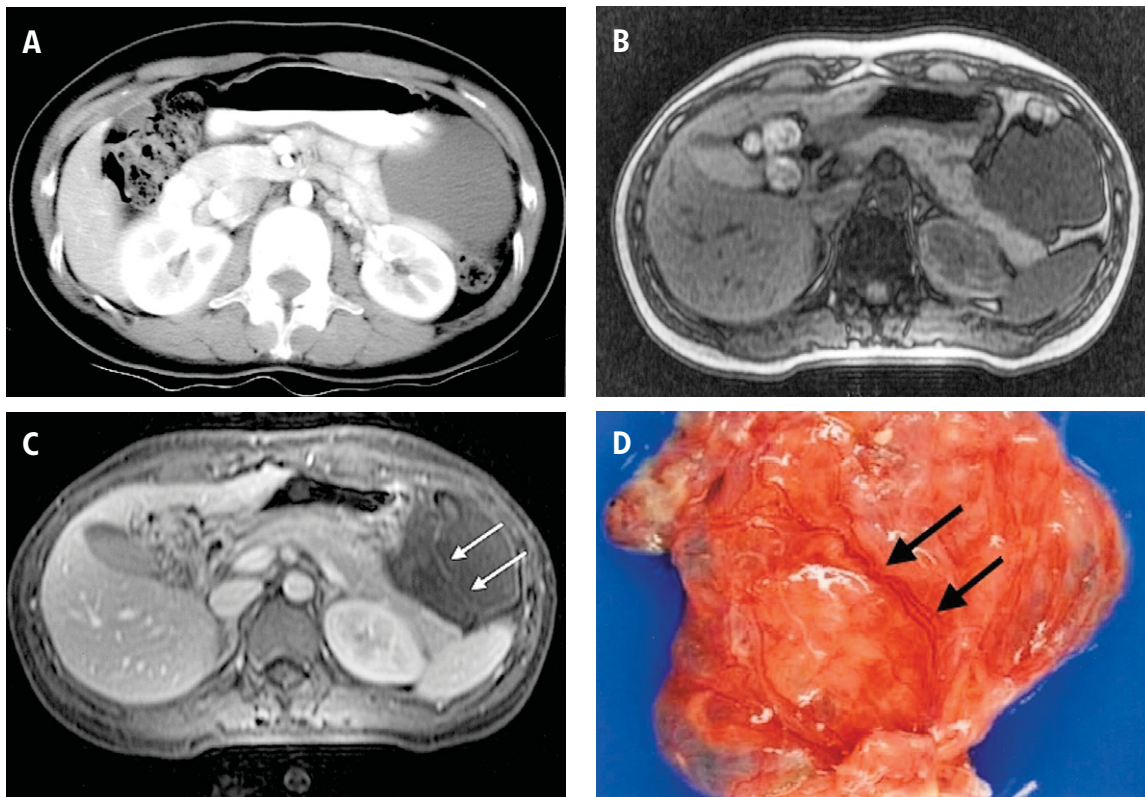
(A) Enhanced computed tomography reveals a thin encapsulated intraperitoneal cyst continuous with pancreatic tail. (B) T1-weighted (TR = 120 ms, TE = 2.2 ms) axial magnetic resonance imaging (MRI) reinforces our imaging diagnosis of a pancreatic tail cystic mass (homogeneous hypointense appearance). (C) Gadolinium-enhanced axial MRI shows a hyperintense thin septum (arrows) within the cystic mass. (D) Grossly, the major cyst is composed of multiloculated cystic spaces with transparent thin wall and thin septum (arrows), which corresponds to the findings in (C).
